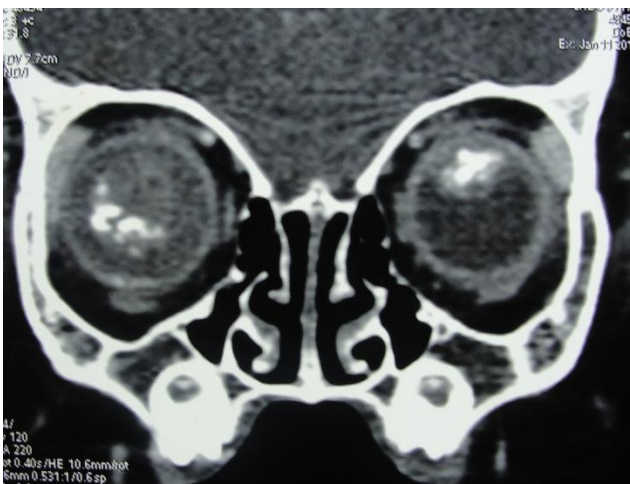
CT Scan of a 4 month old male patient having bilateral retinoblastoma showing intraocular calcification.
